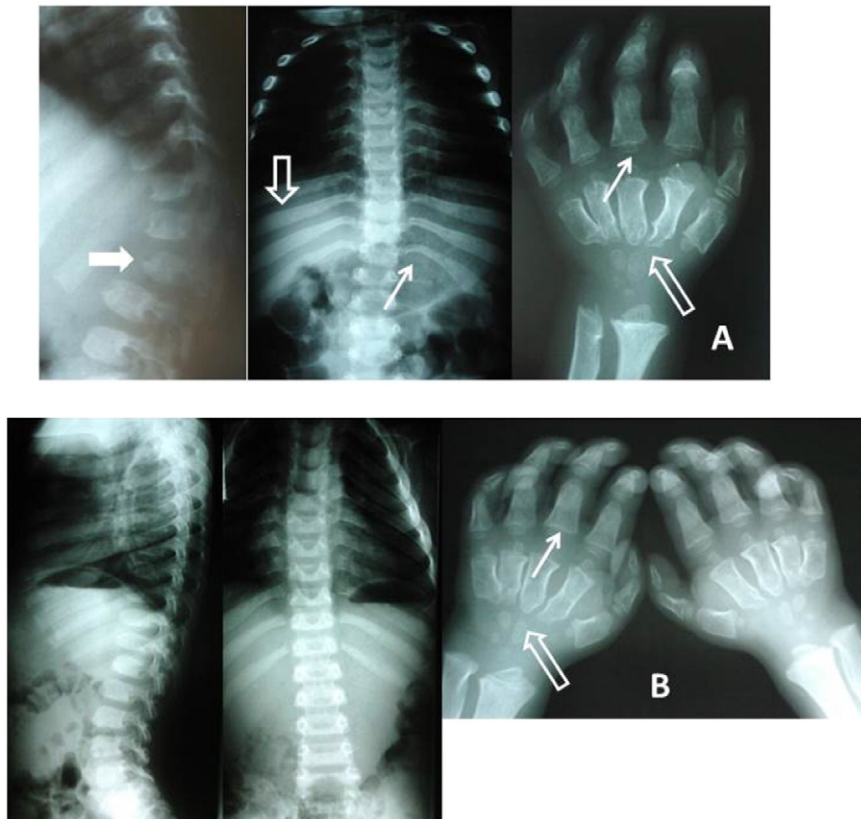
Comparative X-rays at age 6 years. A – older sister of P1: note dysostosis multiplex, with abnormal vertebrae (rounded vertebral bodies with the “anterior beaking” aspect – white arrow – and posterior scalloping), abnormal ribs (tapered proximally – full arrow, and wider distally – empty arrow) and hands (broad and proximally pointed short metacarpals – empty arrow, bullet shaped phalanges – full arrow); B–P1: milder vertebrae abnormalities, dysostosis in hands (same pattern as sister, pointed by arrows).
